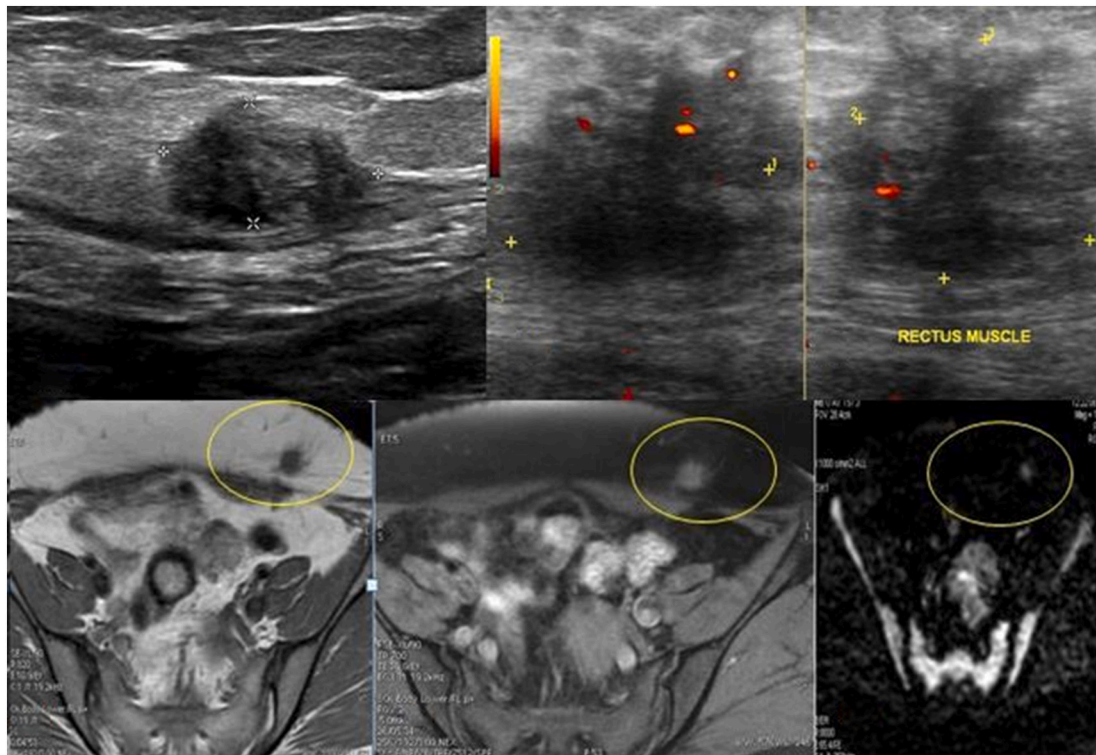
USG TRANSVERSE image superior to the umbilicus reveals avascular, irregular hypoechoic mass with posterior acoustic shadowing. On colour doppler, mild internal vascularity seen.
